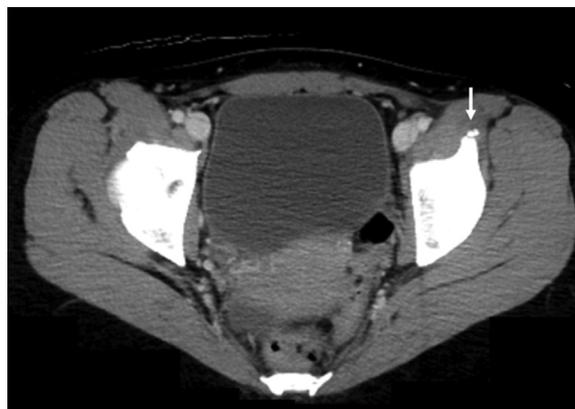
Axial pelvic CT showing calcification at the left anterior inferior iliac spine (arrow).
